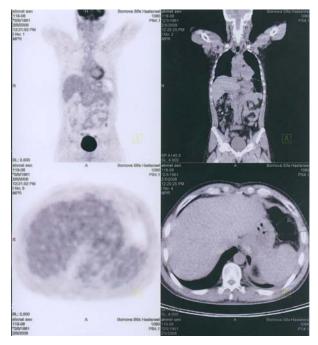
F18-FDG PET/CT showed total loss of FDG uptake in tumor indicating a sustained complete metabolic response.
